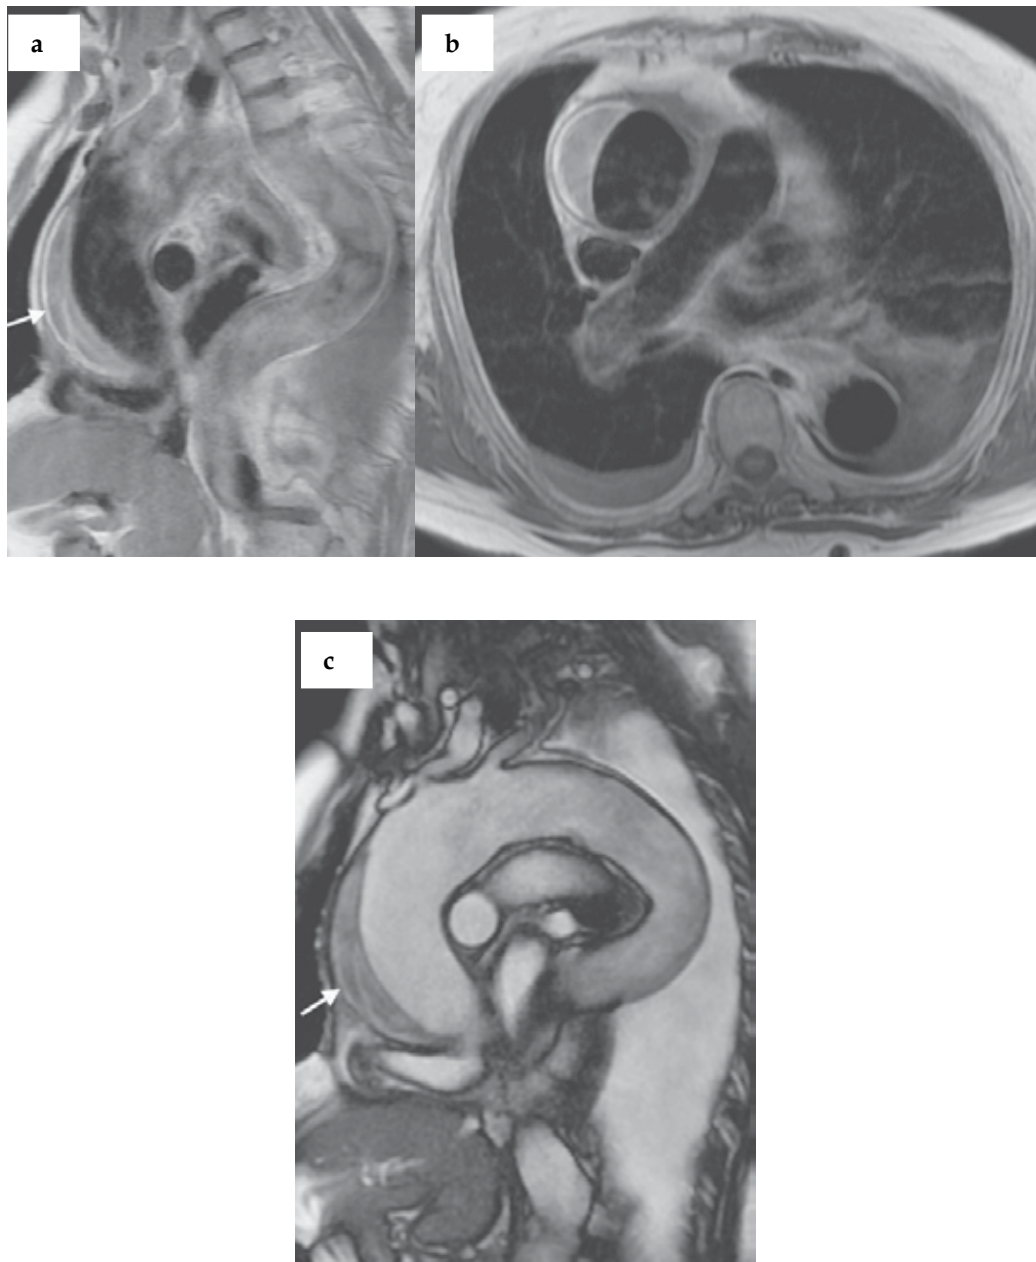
Double inversion recovery spin echo MR imaging of intramural hematoma (a, b). On a T1-weighted spin echo MR image, intramural hematoma of the ascending thoracic aorta shows a crescentic local wall thickening with high signal intensity (arrow, a) caused by the presence of methemoglobin (subacute stage). Two-chamber view oblique sagittal bSSFP (c) shows in the same topography, a crescentic low signal intensity area.
